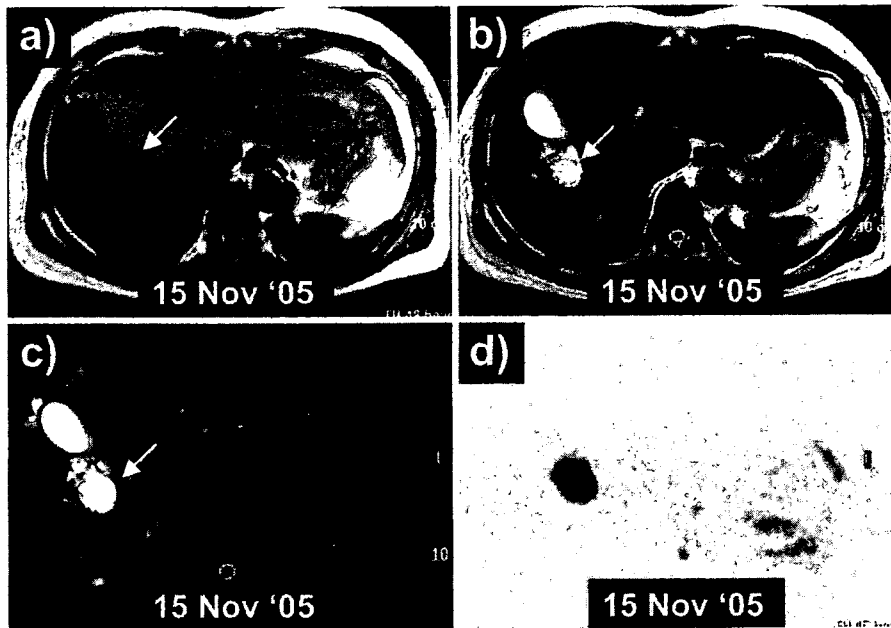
The corresponding MR image showed necrotic or abscess-forming lesions (arrows); a) T1-weighted images, b) T2-weighted images, c) fat-suppressed T2-weighted image, d) inverted diffusion-weighted images.
